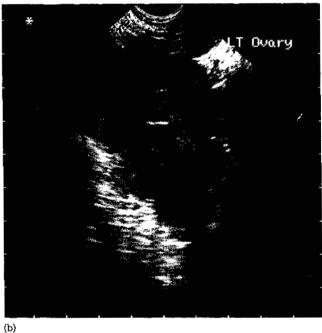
(a) Transvaginal ultrasound scan of unifollicular development in a polycystic ovary and (b) an overstimulated polycystic ovary. Reproduced from Balen and Jacobs (1997), with permission.
